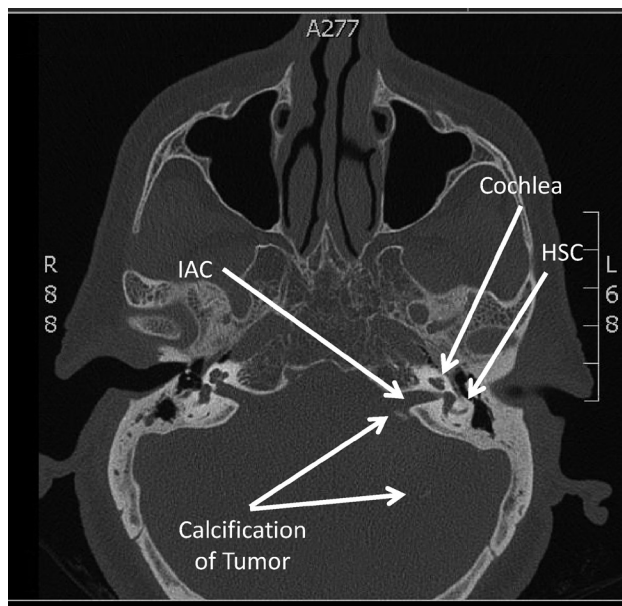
This axial CT of temporal bones demonstrates small foci of calcification in the area of the tumor. IAC stands for internal auditory canal, and HSC for horizontal semicircular canal.
